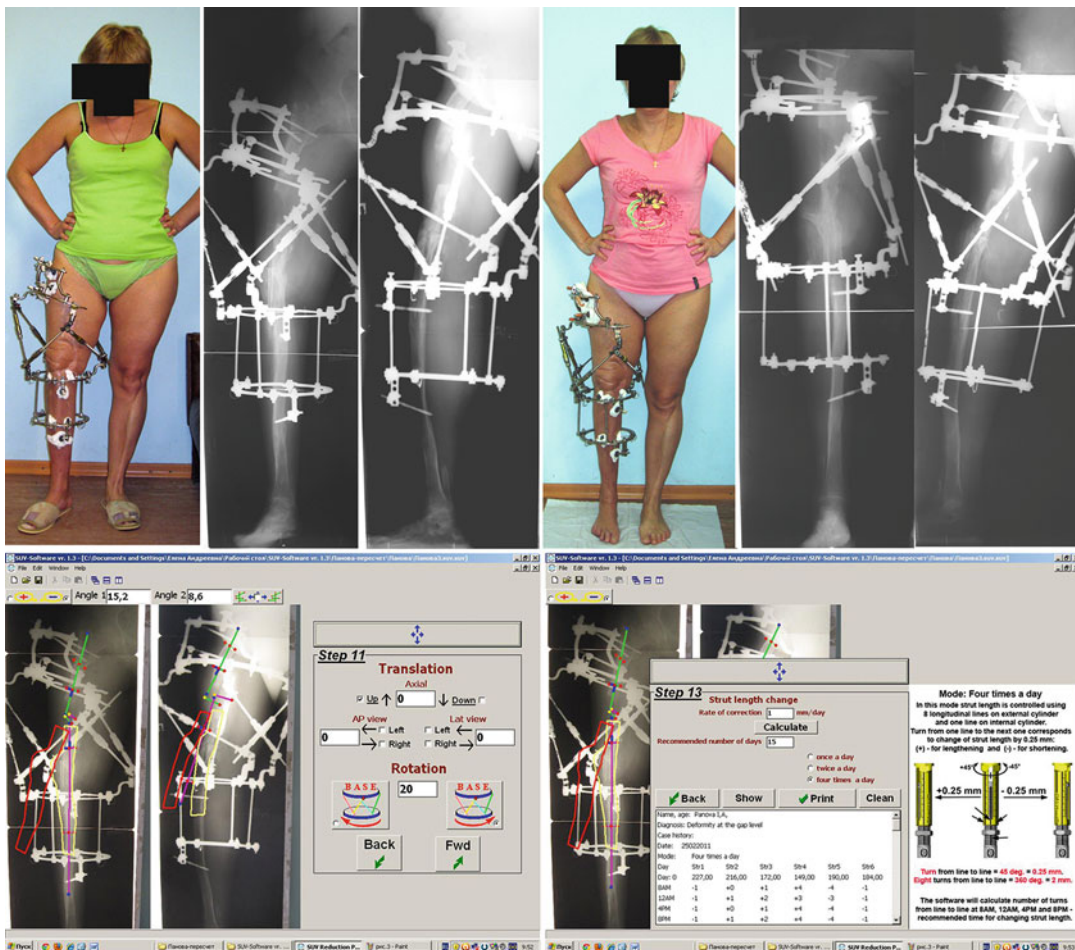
Limb realignment using the hexapod frame (Ortho-SUV Frame)
